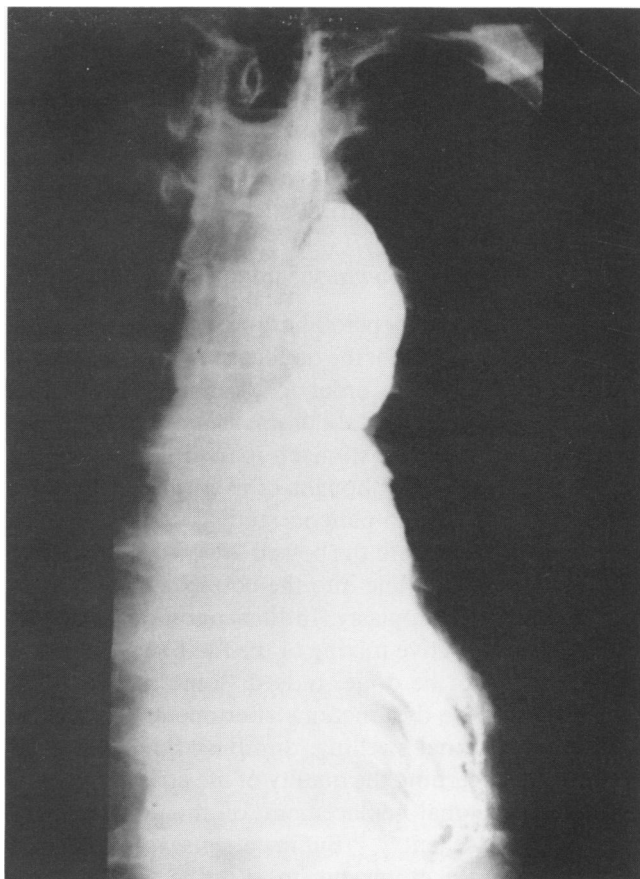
Roentgenogram in head down position in one long-term survivor with left intrathoracic esophagogastrostomy. The new fornix was filled with the contrast medium and no reflux was observed.
